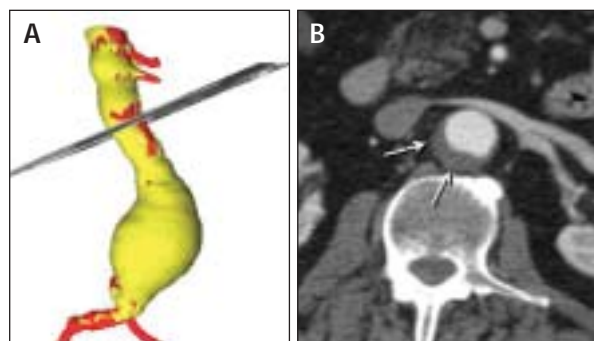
The CT slice location in the proximal neck is shown from a 3-D model (A) in which the CT slice is placed and reformatted to lie in an orthogonal plane. The CT slice shows a thick rim of what appears to be thrombus (arrows) (B). This patient was advised to have open surgical repair to avoid the risks of renal artery embolism and insecure proximal fixation and sealing.
